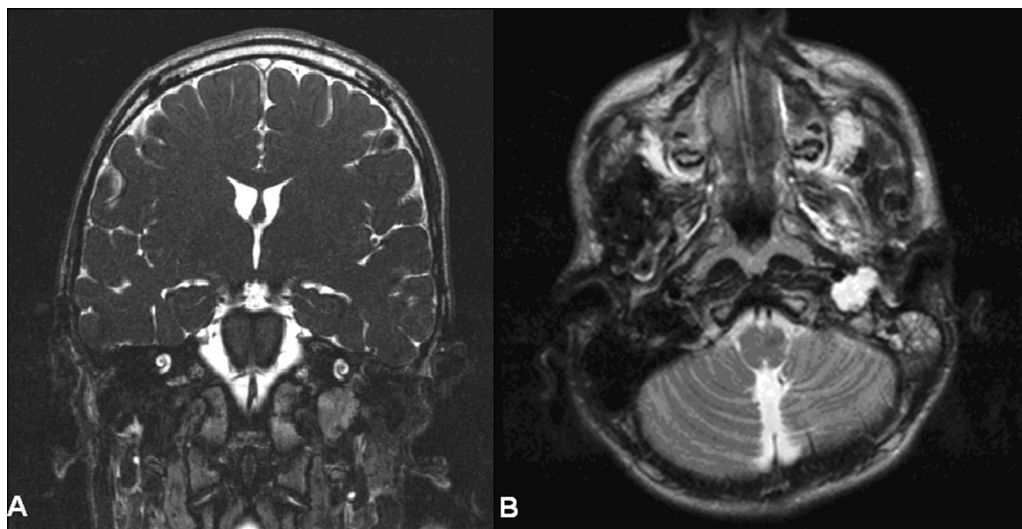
Magnetic resonance imaging showing the infralabyrinthine cholesteatoma of the left side. (A) Coronal T1-weighted magnetic resonance imaging showing extent of infralabyrinthine cholesteatoma of the left side. (B) Axial T2-weighted magnetic resonance imaging with infralabyrinthine cholesteatoma on the left side adjacent to the internal carotid artery.
